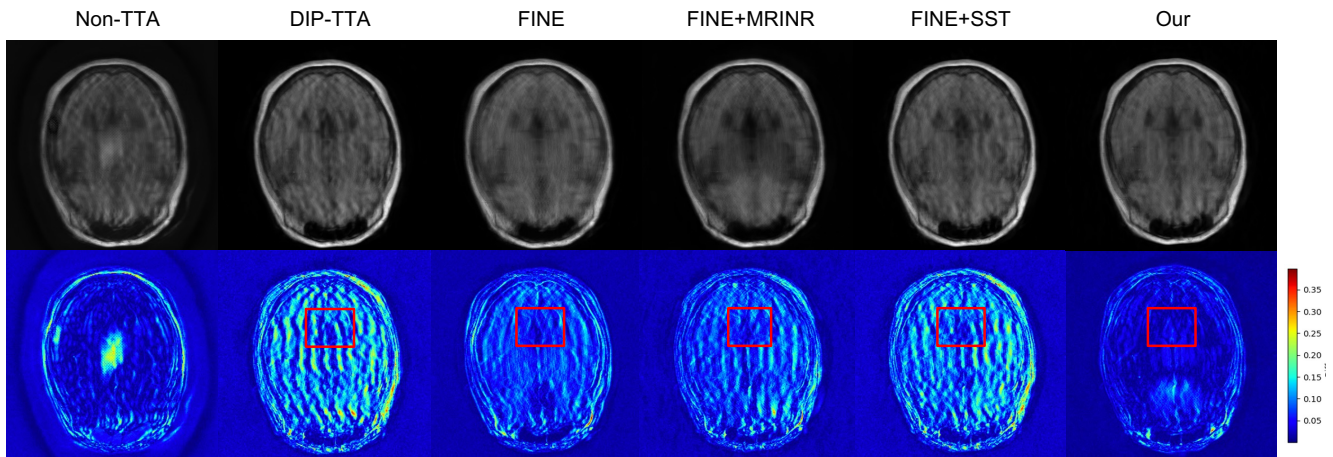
Comparison of different frameworks in Unet under modality shift (AXT2 to AXT1PRE) using the FINE method. The first row shows reconstructed MRI images, while the second row presents residual maps between reconstructions and full-sampled MRI.
